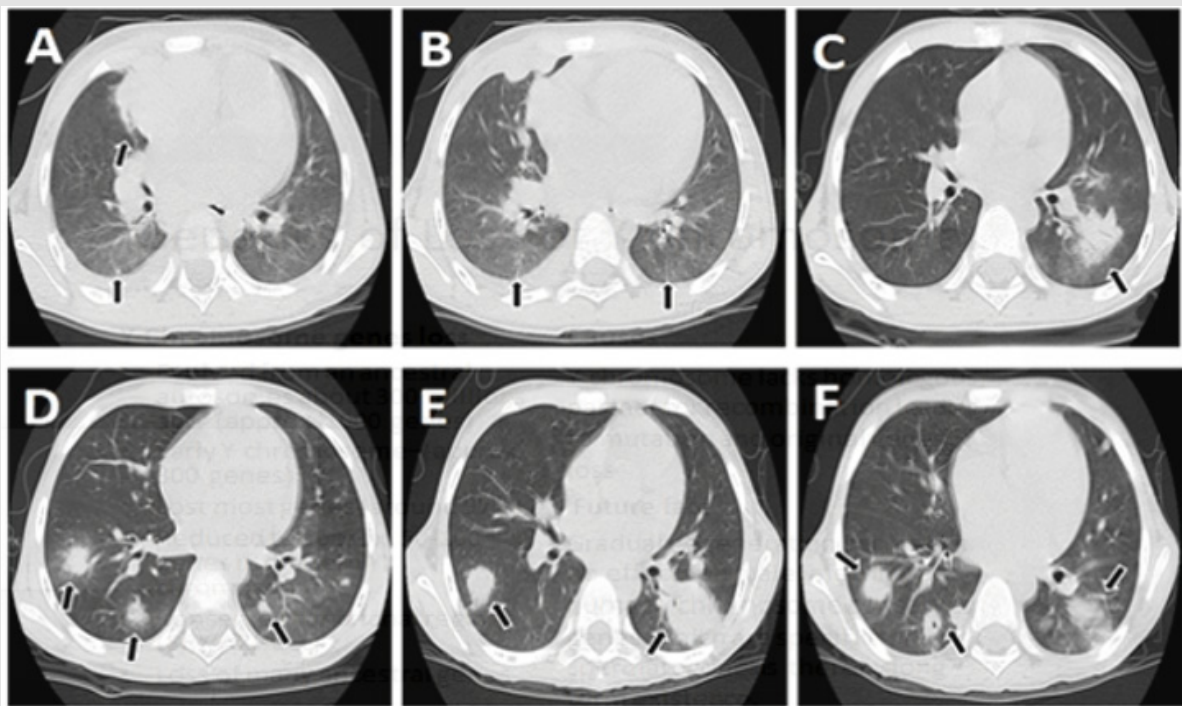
High-resolution CT scan of the chest. Arrows in Figure A and B: A little exudation in both lungs was observed (2 days before chemotherapy). Arrows in Figure C and D: Compared with that before chemotherapy, multiple patchy shadows with increased nodular density were found in both lungs, and fungal infection in both lungs was considered (day 16 of chemotherapy). Arrows in Figure E and F: Compared with the previous two times, more multiple patchy shadows with increased nodular density were found in both lungs, and small hollow shadows were seen in some lesions (day 38).
